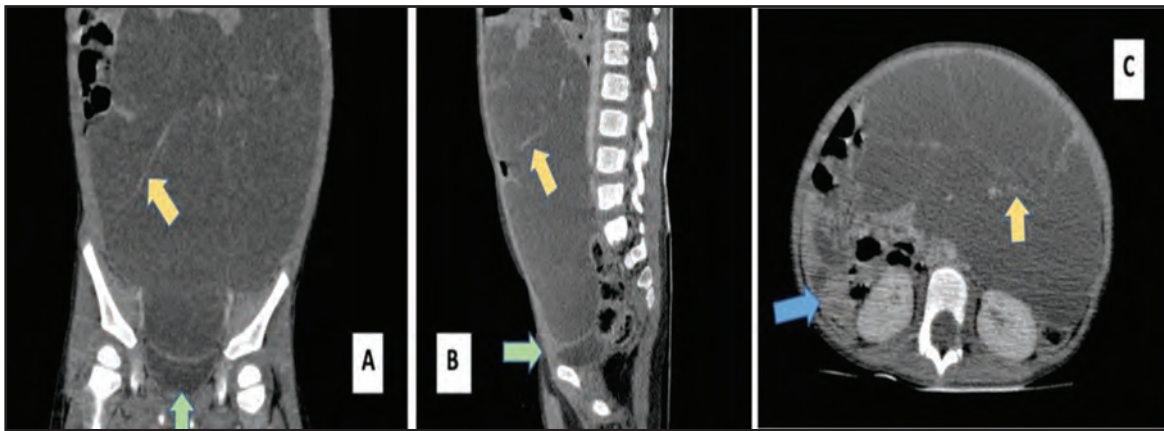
Computerized tomography contrasted computed tomography (CT) scan images in coronal. (a) sagittal (b) and axial (c) images shows large multiloculated intraperitoneal mesentery cystic mass within the abdomen (which is centrally located), below the subhepatic region and extends inferiorly until the pelvis (superior to the urinary bladder- green arrow). Bowel (blue arrow) is displaced postero- laterally by the large cystic mass. No extension of the mass into the spinal canal. Presence of multiple thin enhancing septa (yellow arrow) within the mass. No solid lesion seen within the cystic component.
